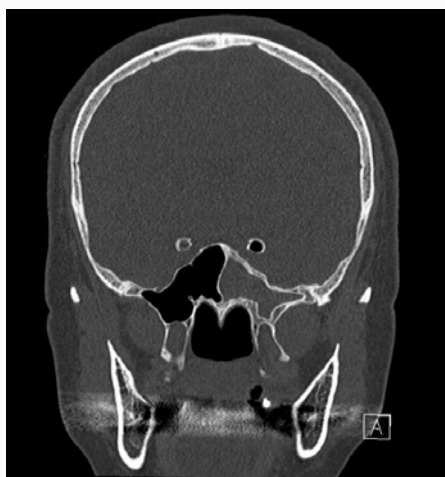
Preoperative evaluation. Using the Computed Tomography (CT) soft tissue density-heterogenous lesion of left sphenoid sinus was confirmed.
